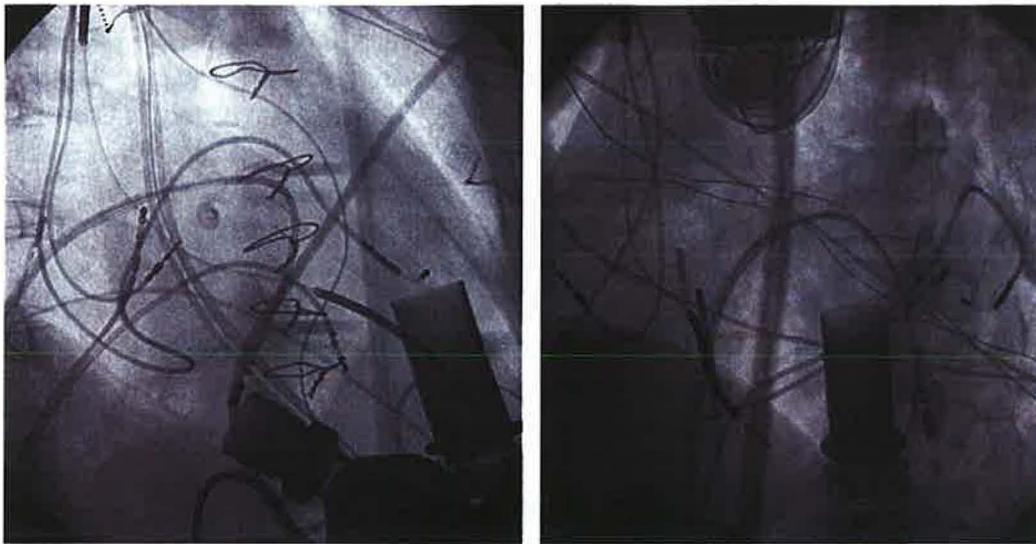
Fluoroscopic (X-ray image) of electrophysiology catheters (above) in patient with LVAD and electroanatomical 3D voltage map (computerized reconstruction) of left ventricle (below). Ablation (tagged red dots) is performed around an area of scar (low voltage) where pacemapping mimics VT morphology. Color scale represents voltage (red-orange is lowest and purple is normal).
